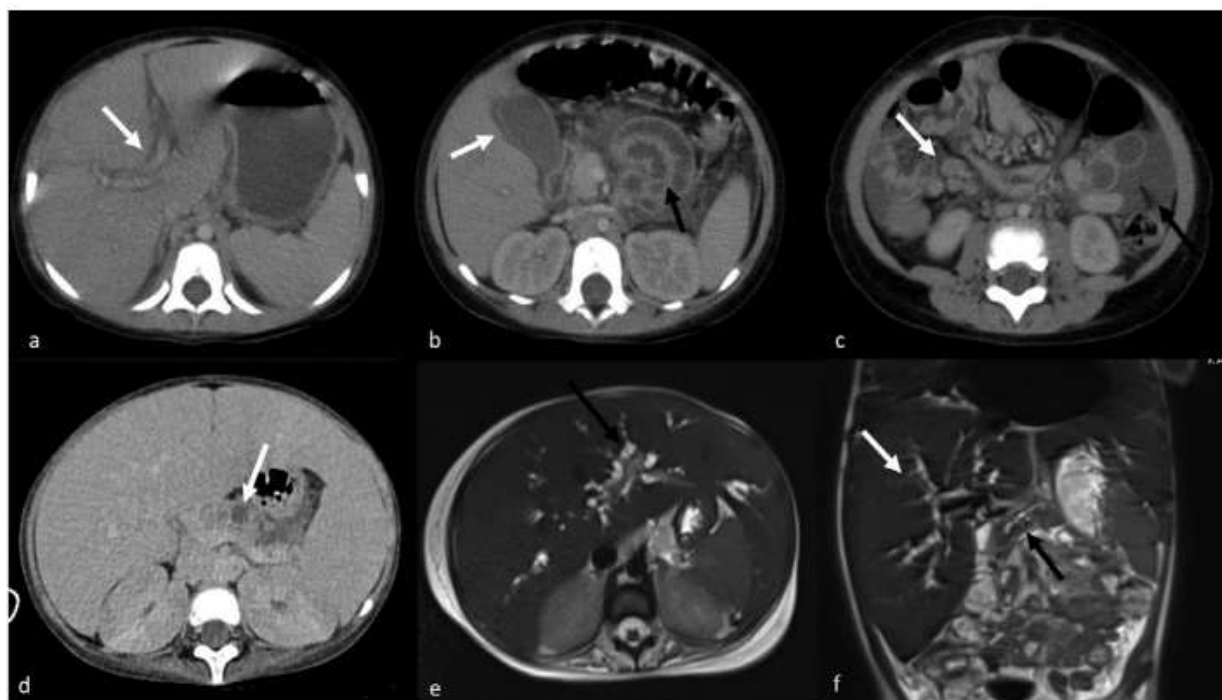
Abdominal CT scans of a 23-month-old girl demonstrate periportal edema (white arrow, *a*), gallbladder edema (white arrow), and intestinal wall thickening (black arrow, *b*). Additional findings include multiple lymph nodes in the right lower quadrant (white arrow) and free fluid (black arrow, *c*). In a 4-year-old female, an abdominal CT reveals pancreatic atrophy, heterogeneous parenchyma, and necrotic regions (white arrow, *d*). MRCP images of the same child show dilated intrahepatic bile ducts and an enlarged main pancreatic duct (e, f) [66].
